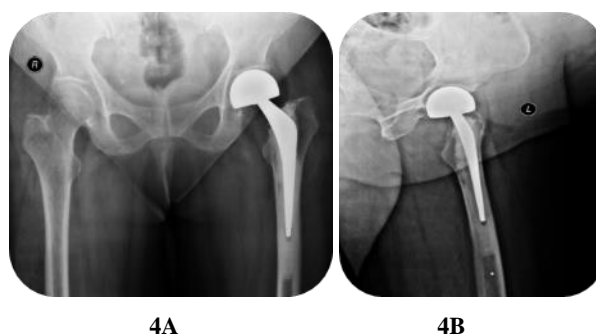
4A, 4B Postoperative x-rays of cemented bipolar hemiarthroplasty
